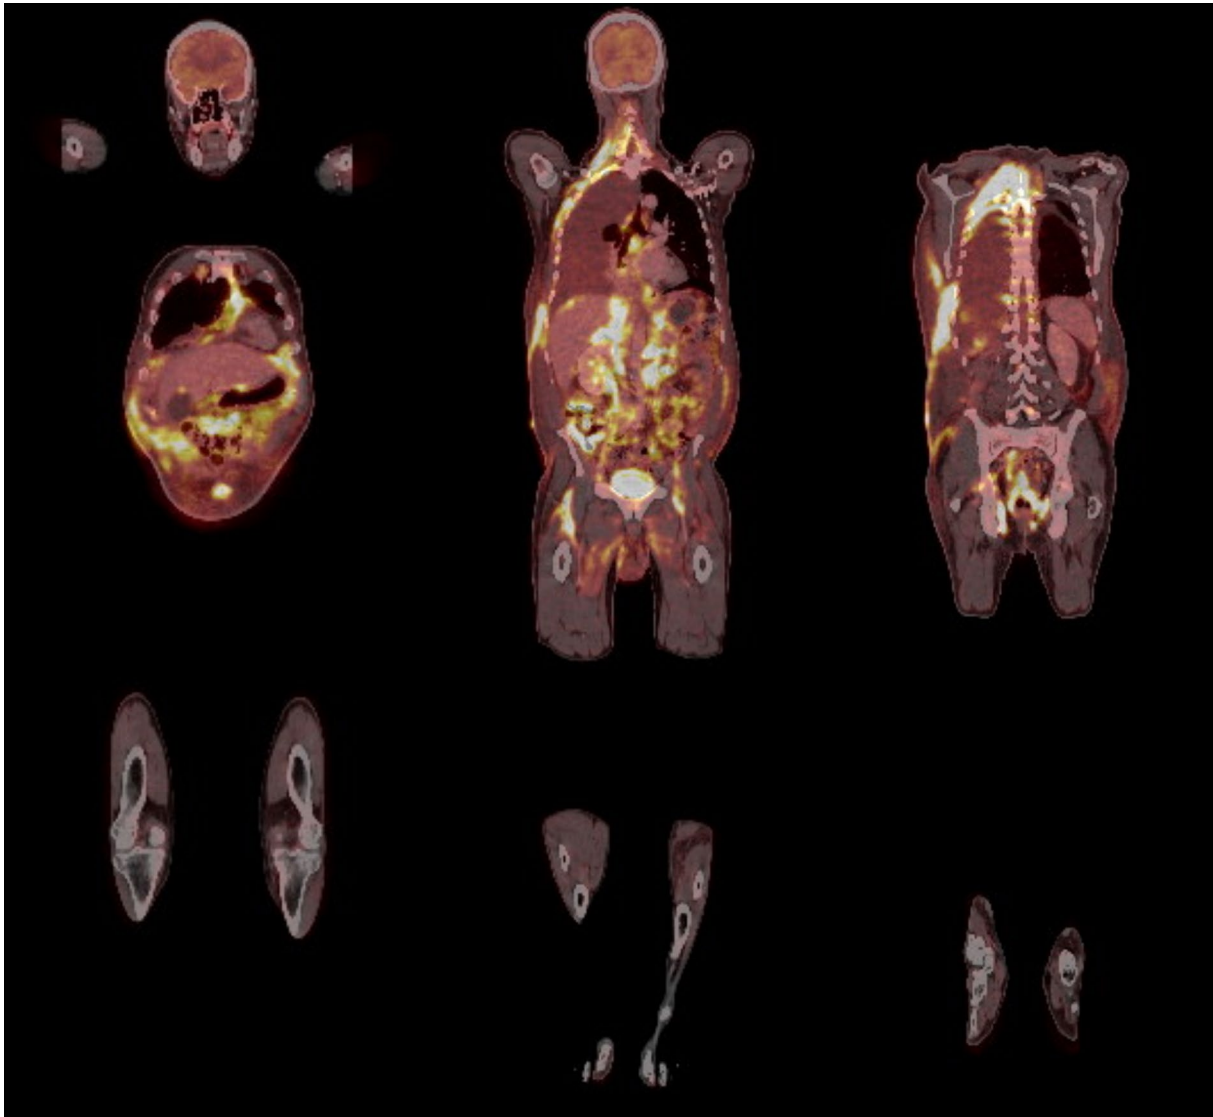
Representative coronal slice from a whole-body PET/CT scan. The imaging demonstrates extensive hypermetabolic infiltration of cervical, dorsal, and lumbar muscle planes, particularly on the right side, with notable involvement of subcutaneous adipose tissue and retroperitoneal structures. Bilateral pleural effusion, hypermetabolic mediastinal and retroperitoneal adenopathies, and omental thickening
